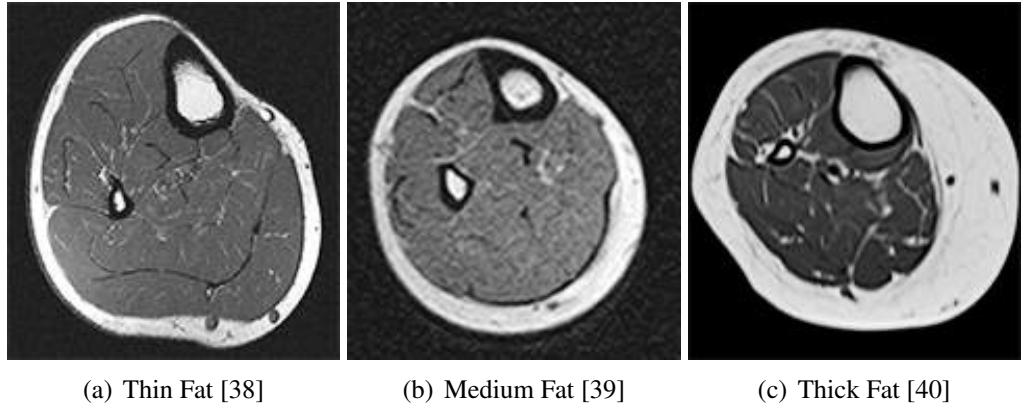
Three cross-sectional MRI images representing three fat layer thicknesses.
